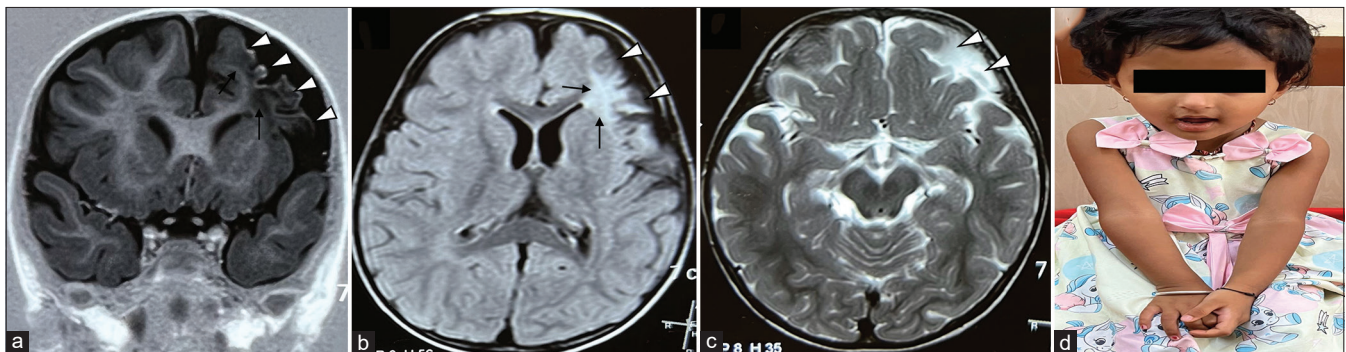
(a) Magnetic resonance imaging brain with T1-weighted coronal (white arrow heads), (b) T2-weighted axial (white arrow heads) and (c) short tau inversion recovery axial sequences show loss of left frontal lobe volume (white arrow heads) with gliotic ischaemic areas (thin black arrows [in a-c]) in cortex and subcortical white matter regions, (d) clinical photograph of the child during the last follow-up at three years showing mild residual weakness of the right upper limb.
